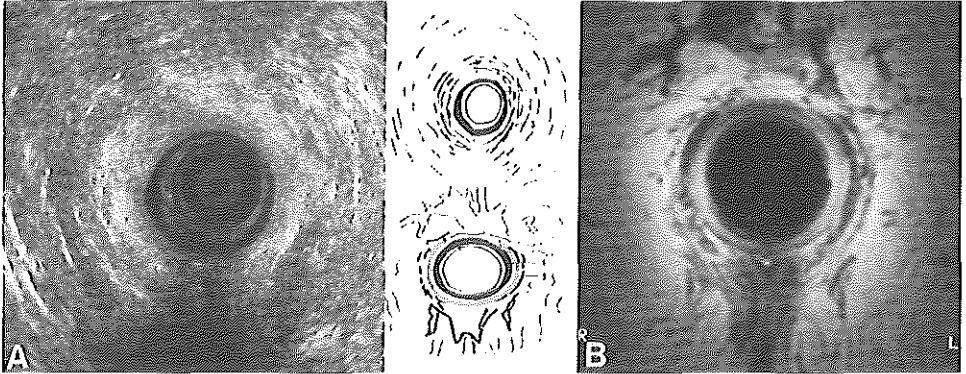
Atrophy. Axial sonography (A) and MRI (B) in a female (67) who gradually became incontinent during recent years. With sonography there is a defect anteriorly whereas with MRI an extreme thinning of the external sphincter (3) is visible. The internal anal sphincter (1) is normal.
